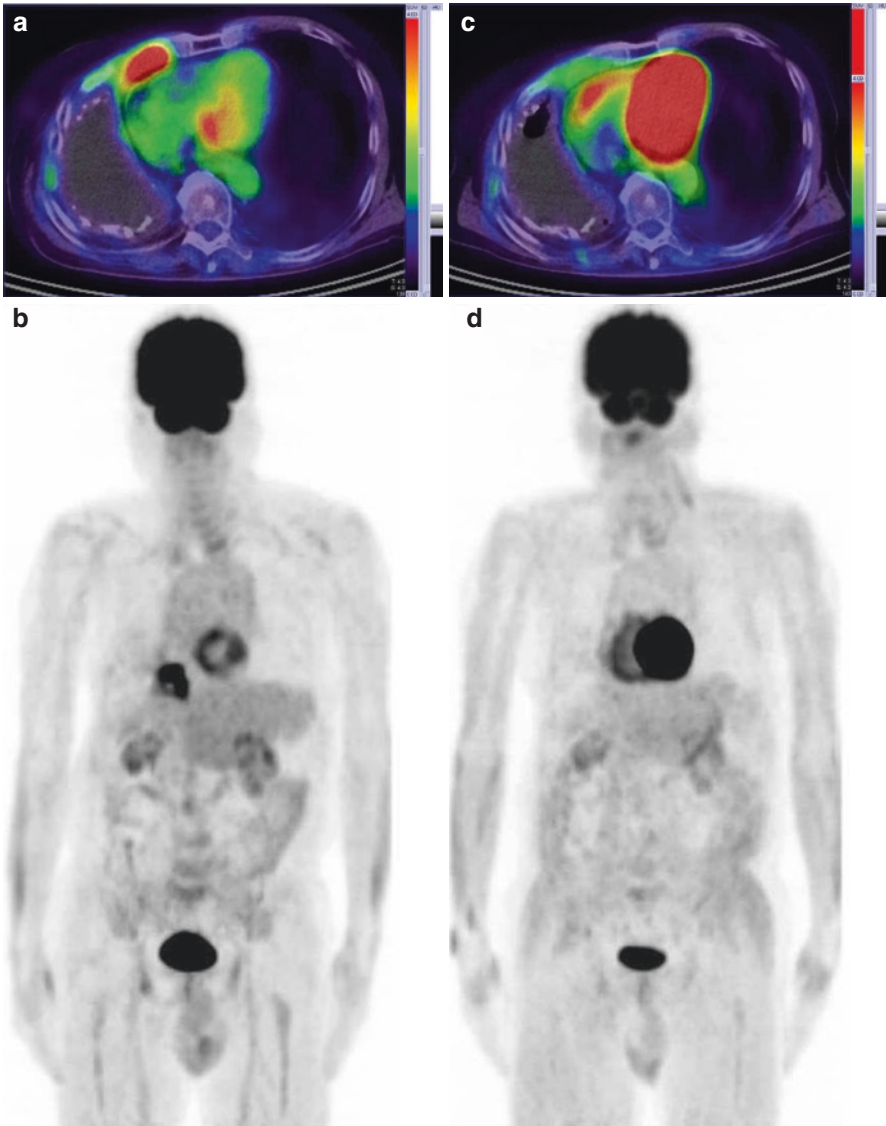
FDG PET/CT images of an 80-year-old male patient with stage I PAL treated by radiation therapy not including pyothorax cavity. The patients lived without relapse more than 5 years after the radiation therapy. (a) Axial image before radiation therapy. PAL lies in the right anterior chest wall neighboring a pyothorax cavity in the right thorax. (b) Maximal intensity projection (MIP) frontal image before radiation therapy. (c) Axial image after radiation therapy. An uptake was no more seen in the right anterior chest wall. (d) MIP anterior image after radiation therapy
